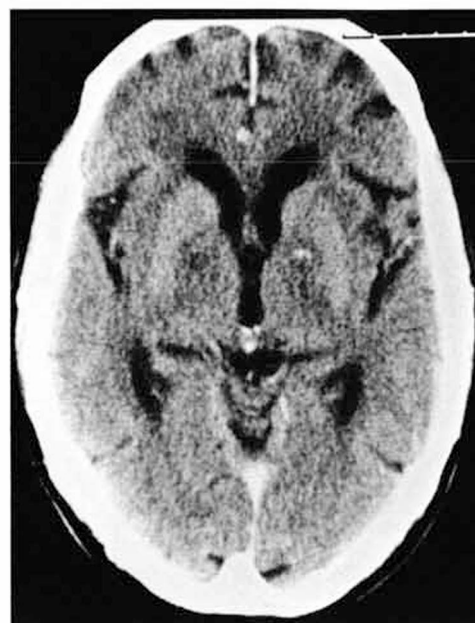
CT scan of patient 4. Small hemorrhage in the left lentiform nucleus with surrounding edema.
